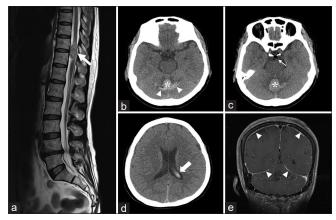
Case 2. (a) A T2-weighted sagittal spine magnetic resonance imaging revealed a 13 × 15 × 27 mm-sized intradural extramedullary mass at the T10-T11 level (arrow). (b-d) A brain computed tomography revealed an acute intracranial hemorrhage in the superior cerebellar vermis (asterisk), a subarachnoid hemorrhage in both cerebellar folia (arrowheads), pneumocephalus in the basal cistern (thin arrow), and intraventricular hemorrhage in the left lateral ventricle (thick arrow). (e) A brain magnetic resonance imaging revealed diffuse pachymeningeal enhancement (arrowheads), suggestive of intracranial hypotension
